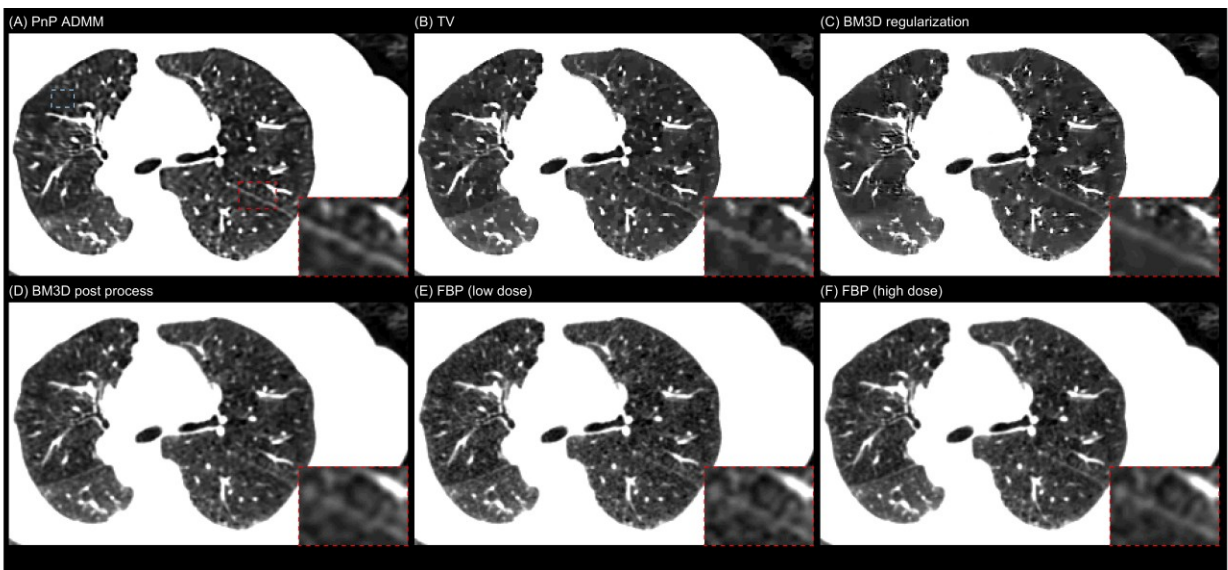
Reconstructed image of the lung patient #2 with zoomed-in view of the fissure line using (A) Plug-and-Play ADMM, (B) TV, (C) BM3D regularization, (D) BM3D post process and (E) FBP from low dose CT data (25% dose), and (F) FBP from standard dose CT data. The conformal region indicated by the blue rectangle is used for standard deviation evaluation in Table 2-4.
